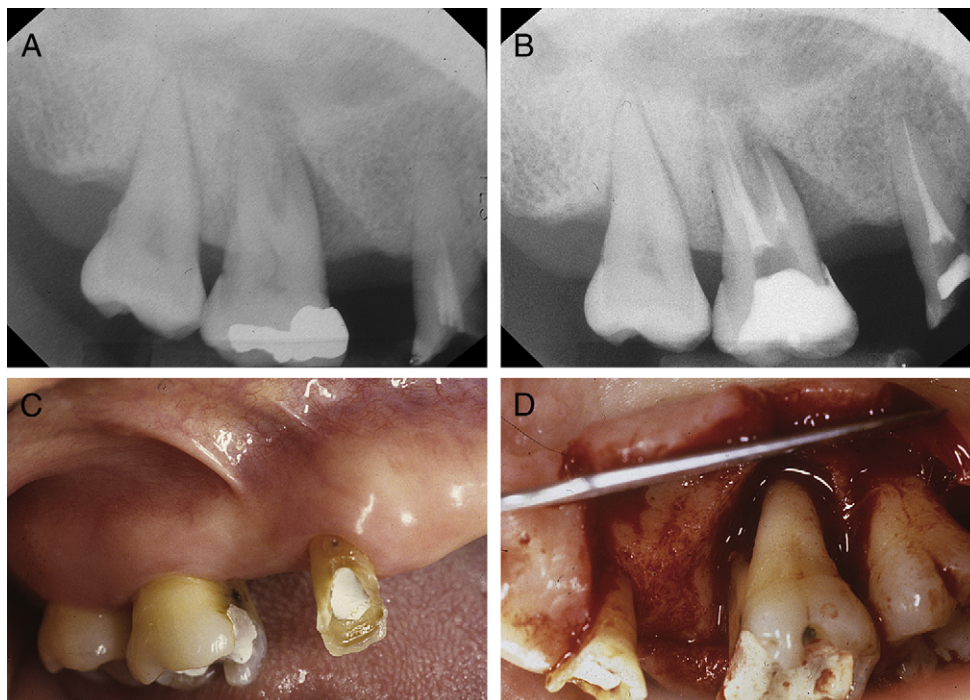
(A) Initial vertical bony defect extended to root apex of tooth #3. (B) Radiograph after root canal treatment and SRP. (C) Preoperative clinical photo. (D) Flap retracted and defect debrided.
